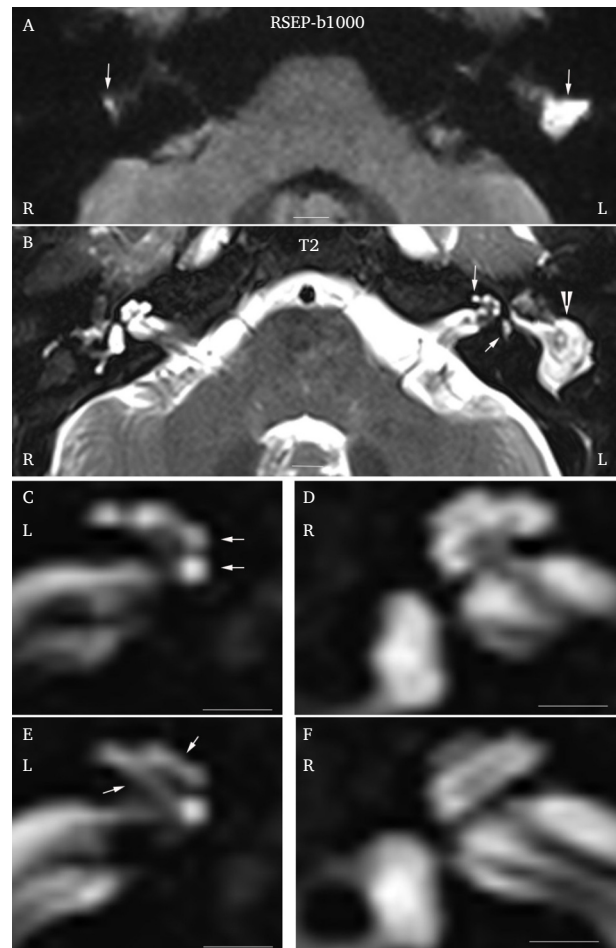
Non-contrast MR image of the temporal bone before surgery in the right ear in 2023. A positive cholesteatoma signal was detected on both sides via a readout-segmented echo-planar (RSEP) imaging-based technique (arrows in A). A nodular bright signal was detected in the left cochlea and vestibule (arrows in B), and a large piece of bright signal was detected in the left middle ear cavity (arrowhead in B) on the T2-weighted MR image. The bright signal in the left cochlea was confirmed as endolymph by T2-sampling perfection with application-optimized contrasts via a flip angle evolution (SPACE) sequence (arrows in C and E) compared with the right side (D and F). RSEP-b1000: b value = 1000 during imaging. Scale bars = 6.0 mm (A-B) and 3 mm (C-F).
